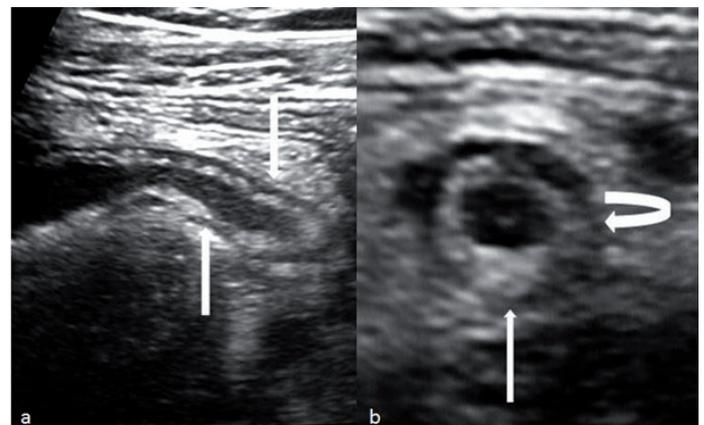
Longitudinally (right) and transverse (left) US images showing a pathological appendix. a. Longitudinal sonogram of an enlarged appendix (solid white arrows). The thick hypoechoic layer represents muscular propria and periappendicitis. b. Axial sonogram shows the ring appearance of enlarged appendix (solid straight and curved white arrows). The asymmetric hypoechoic region represents a muscular layer with periappendicitis.
